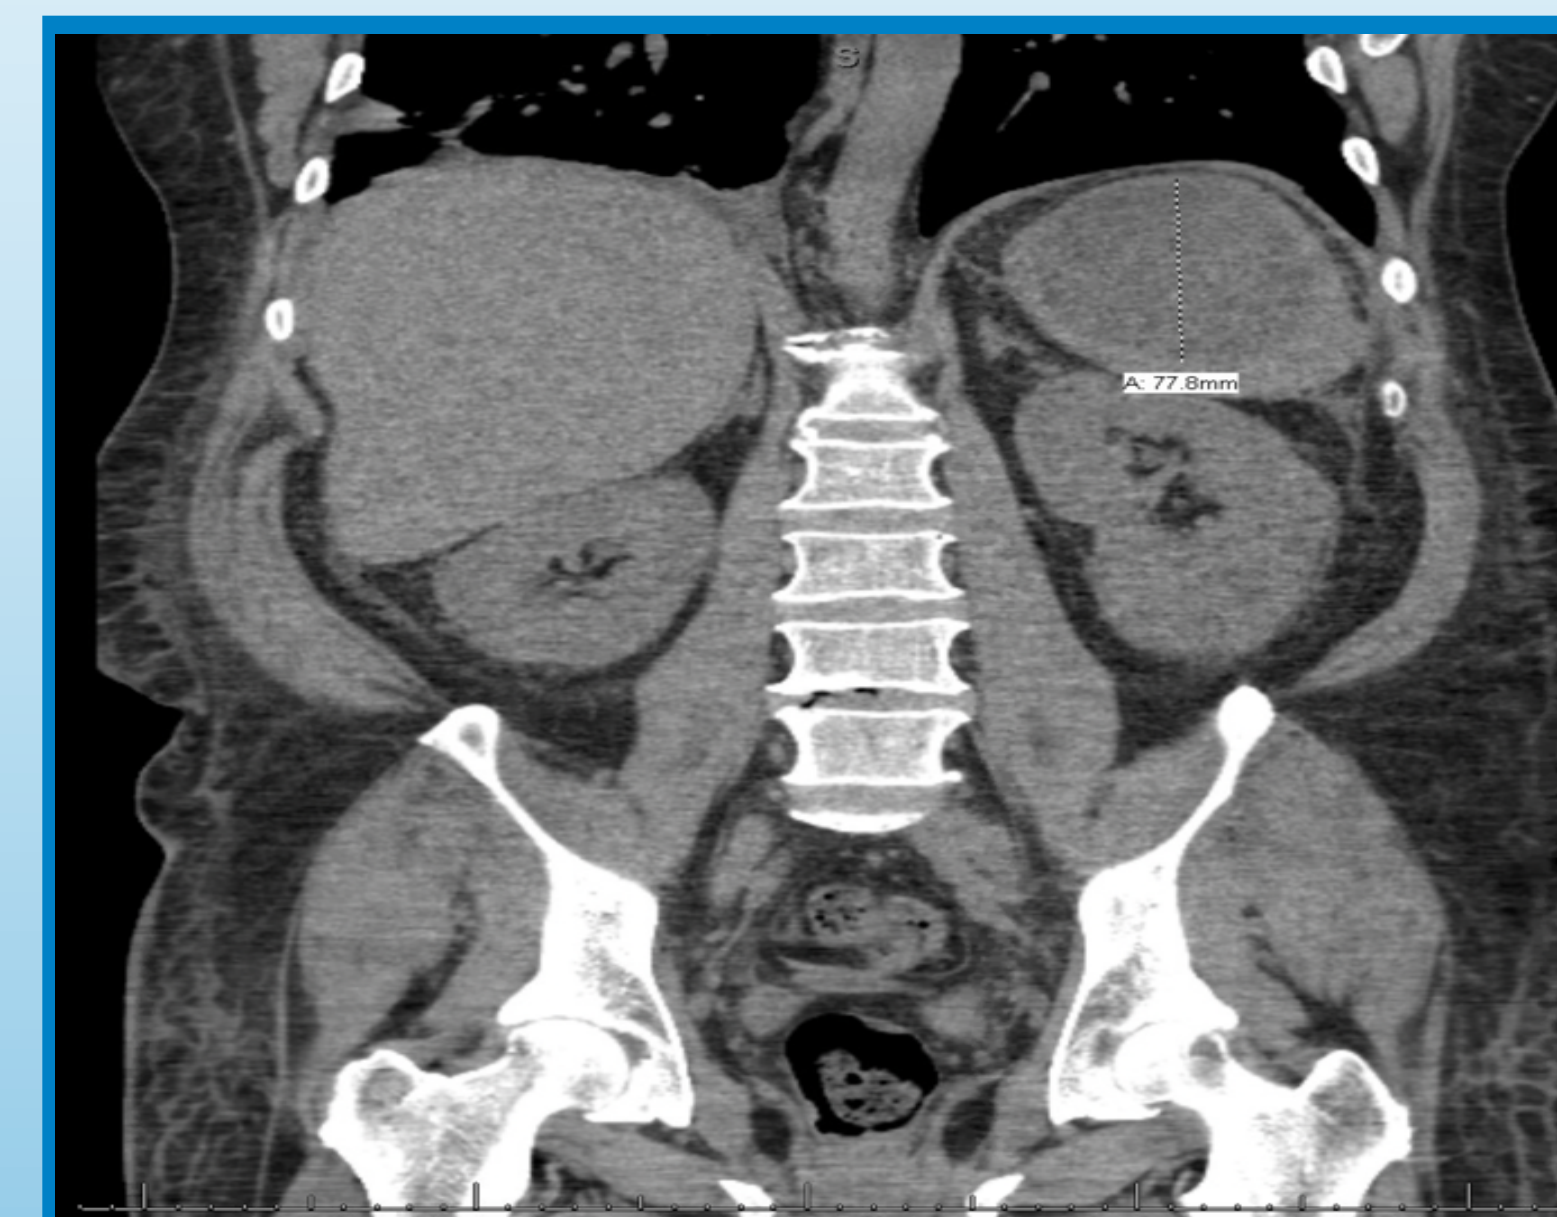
Coronal plane view of the CT abdomen showing the splenic abscess.
